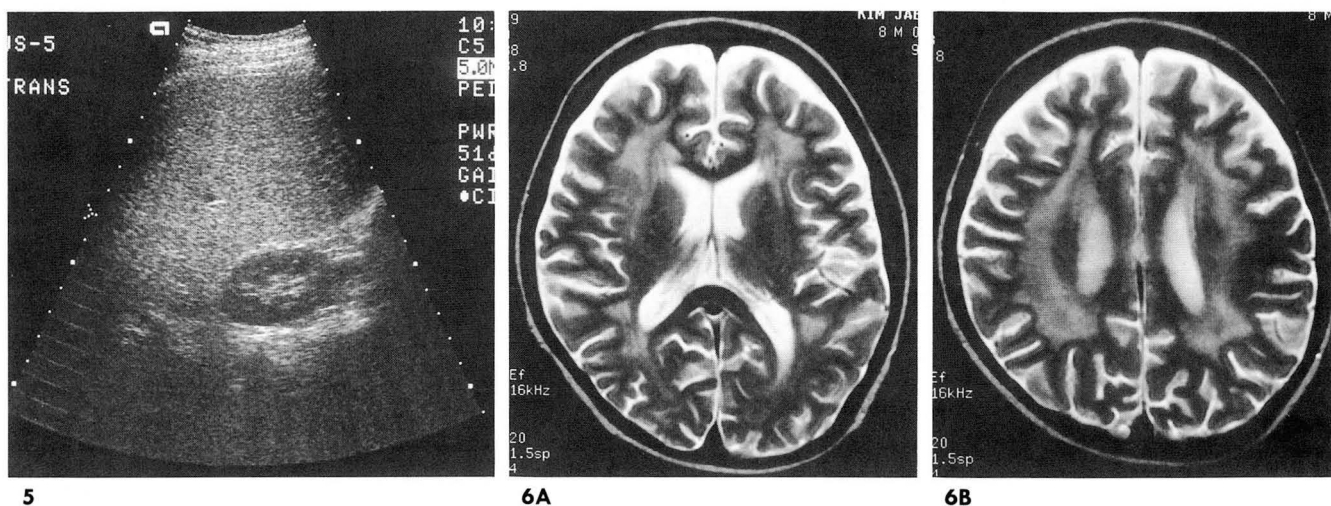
Chemotherapy-induced fatty liver. An 11 year-old boy with acute lymphoblastic lymphoma received chemotherapy with prednisone and methotrexate. Three months later, transaminase level was elevated. Ultrasonography shows diffusely increased echogenicity of the liver as compared to the right kidney, which suggests fatty liver. Biopsy confirmed fatty infiltration in the liver.
